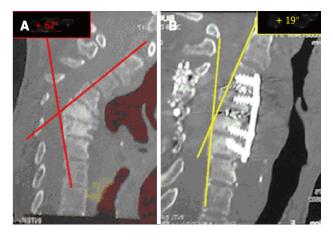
The preoperative computed tomography. A: Scan control (preop. Angle of Jackson + 62°); B: Showing a good reduction of kyphosis (postop angle of Jackson + 19°).
